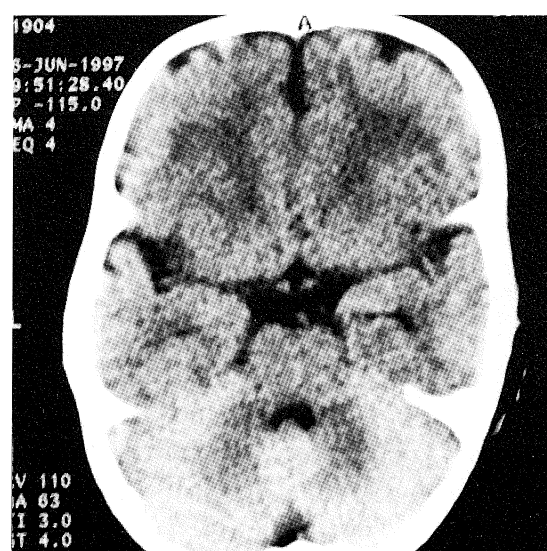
Computed tomography of the brain of a normal newborn showing complete myelination of the cerebellar pons and midbrain.
